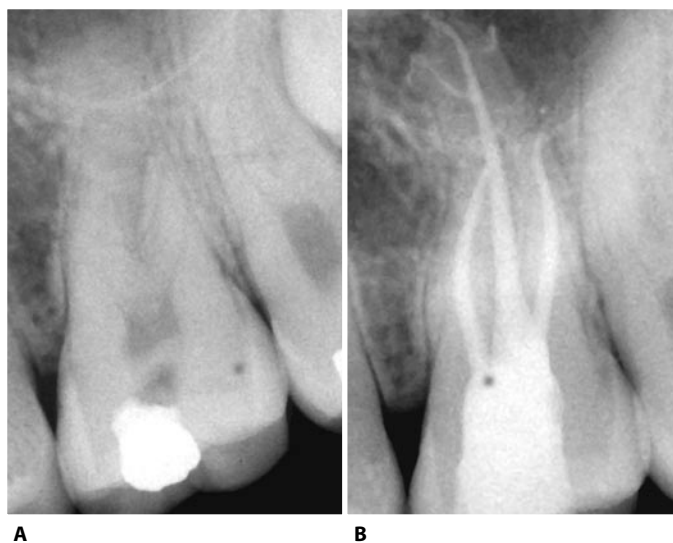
A. Endodontic treatment of an upper left first molar. B. Postoperative radiograph after obturation with standard Therafil reveals a complex canal system associated with the palatal root.
